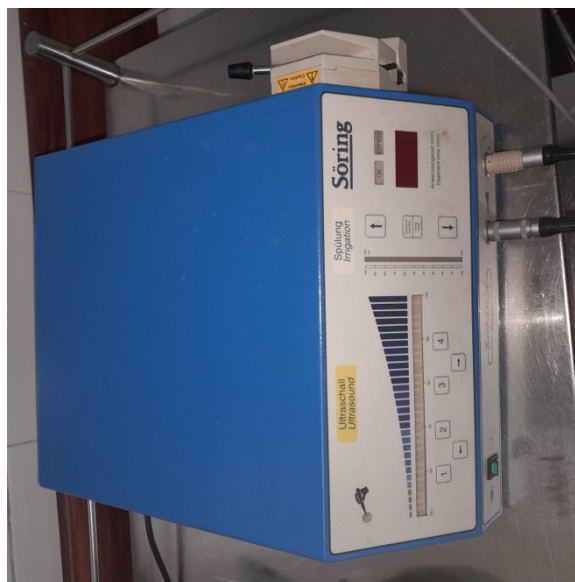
Sonoca 185 ultrasound wave generator.
